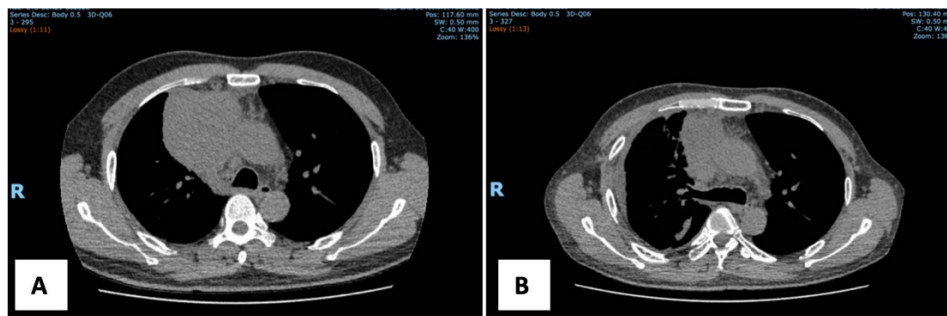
Thoracic CT scan. (A) First examination: there is superior-anterior mediastinal mass with malignant characteristics invading the superior vena cava, size 7.3 cm × 7.4 cm × 9.0 cm. (B) Four months of evaluation: the superior-anterior mediastinal mass is reduced in size, but other pathological lesions persist and even new lesions of pleural and pericardial effusion appear, size ± 5.9 × 6.7 × 7 cm.
